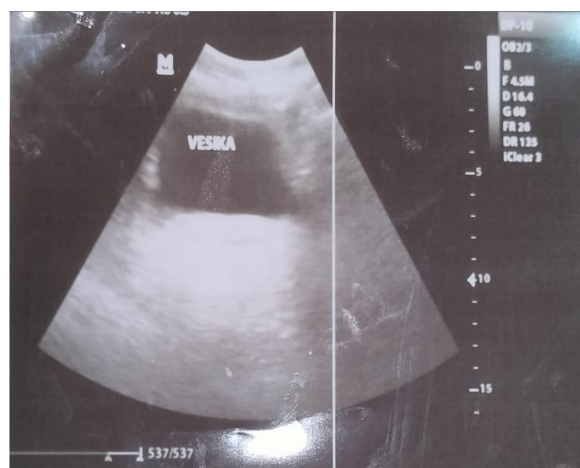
The results of the transabdominal ultrasound examination of the patient showed that there was no enlargement of the uterus, no amniotic fluid, no fetal parts, and no fetal heart rate.
